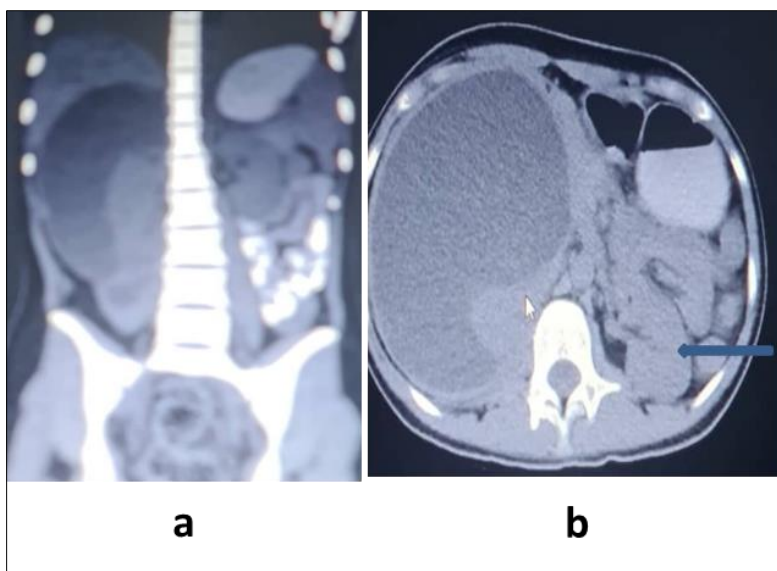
a and 2b are non-contrast enhanced computed tomography (NCECT) coronal reformatted and axial views respectively showing the right calyceal diverticulum, white arrow is showing the right kidney which is compressed by the calyceal diverticulum and the left kidney is seen (blue slim arrow)
